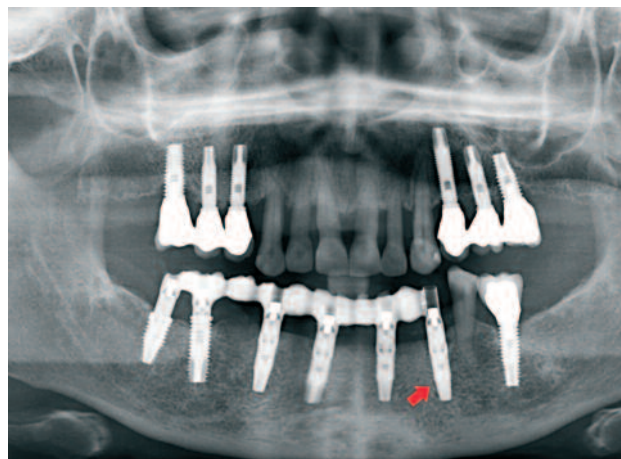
Radiographic image at 3 years. Stability of tissues is maintained.
